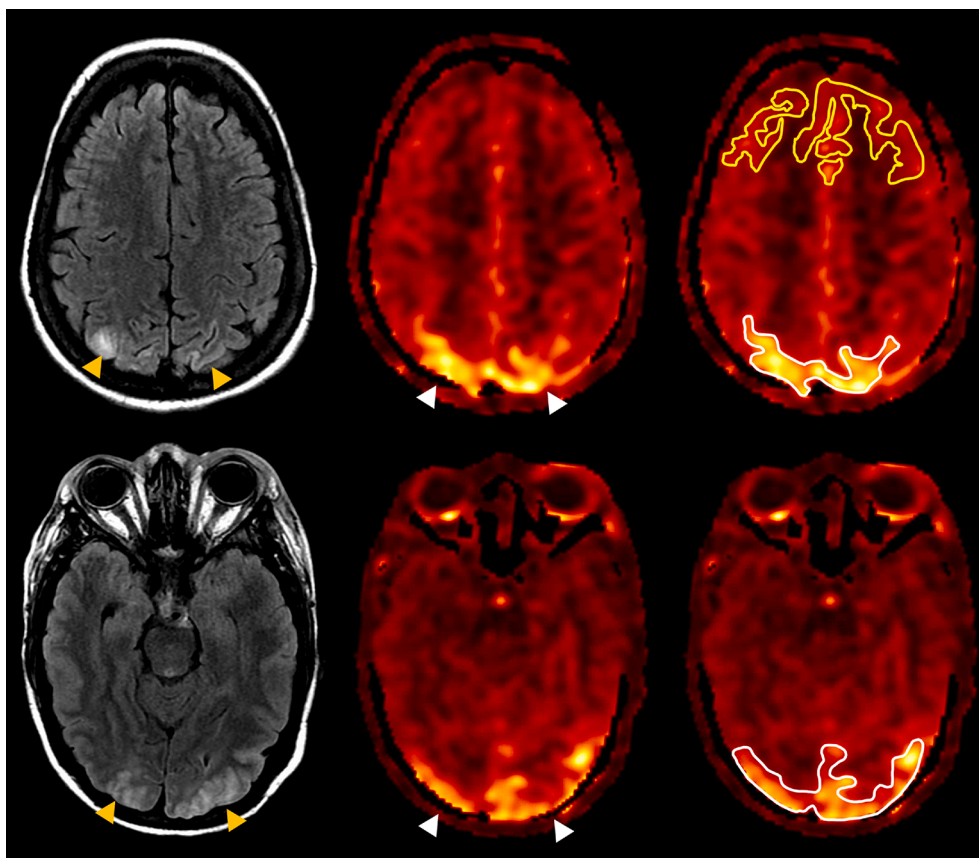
Axial T2 FLAIR (left) and ASL perfusion maps (middle and right) in a 23-year-old female with Tacrolimus-induced PRES. Hyperperfusion (white arrowheads) is noted corresponding to the regions of parieto-occipital FLAIR hyperintensity (yellow arrowheads). Regions-of-interest (ROI) are depicted for hyperperfusion (white outline) and normal perfusion (yellow outline). Note that ROIs extend into adjacent slices (not shown). (For interpretation of the references to color in this figure legend, the reader is referred to the web version of this article.)
